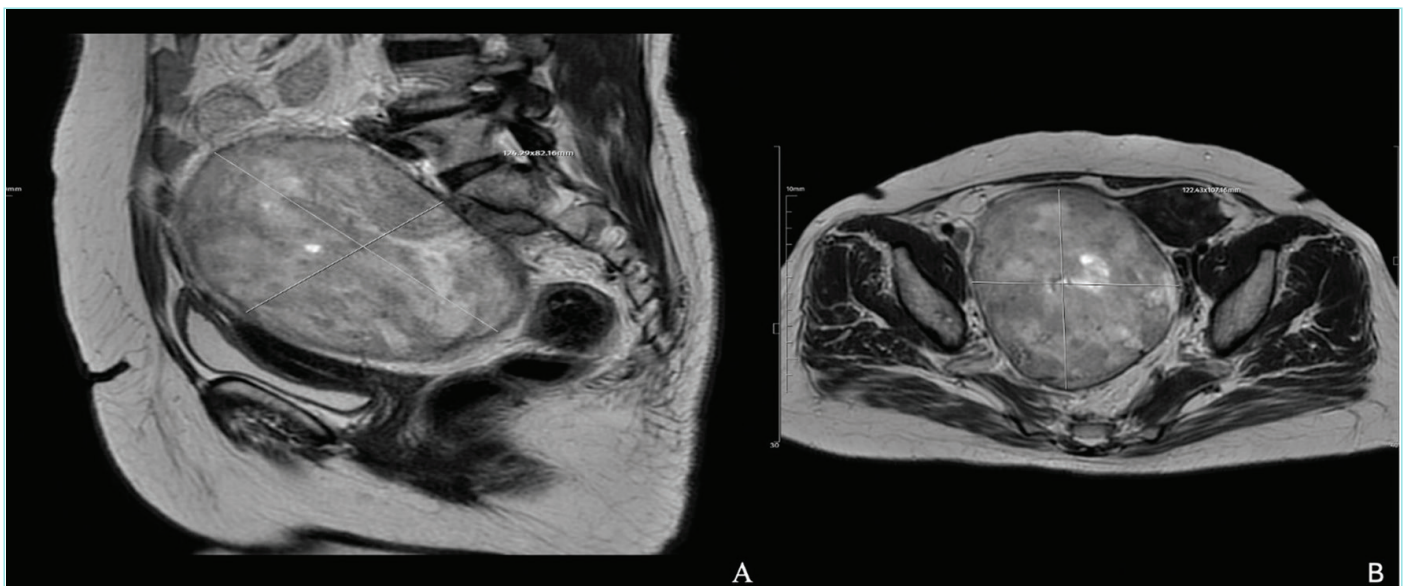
Pelvic magnetic resonance imaging. A) Sagittal view demonstrating a large presacral mass measuring approximately 128×82×122 mm. B) Axial view showing the lesion with a prominent solid component and cystic areas.
